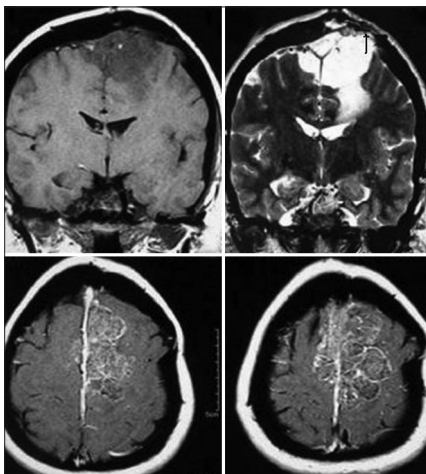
Coronal and axial views of magnetic resonance imaging brain showing a parasagittal lesion which is isointense on T1 weighted images; extremely hyperintense on T2 weighted images and showing scanty contrast enhancement with lobulated margins. Bone invasion can be also be appreciated (arrow)
